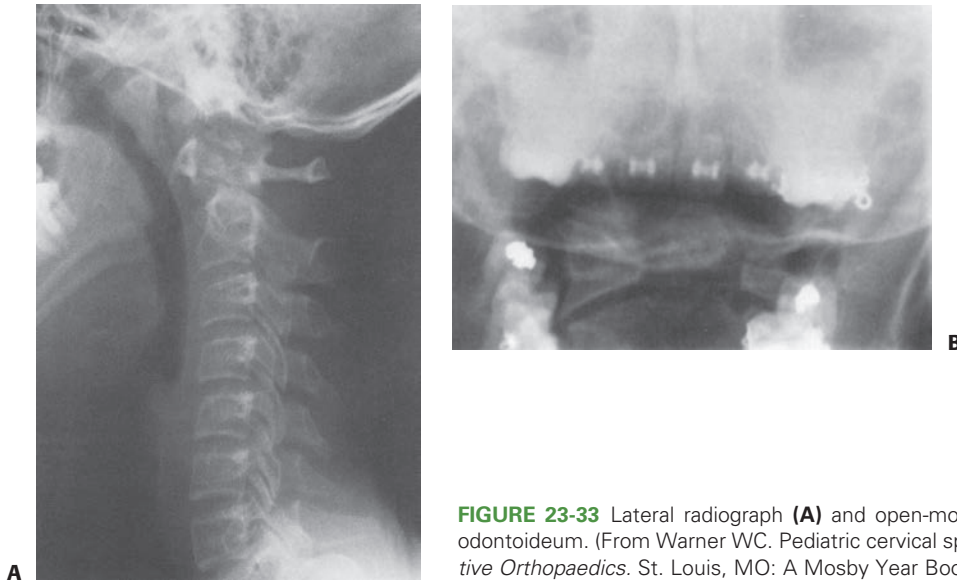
Lateral radiograph (A) and open-mouth odontoid radiograph (B) showing os odontoideum. (From Warner WC. Pediatric cervical spine. In: Canale ST, ed. *Campbell's Operative Orthopaedics*. St. Louis, MO: A Mosby Year Book, 1998:2817, with permission.)
